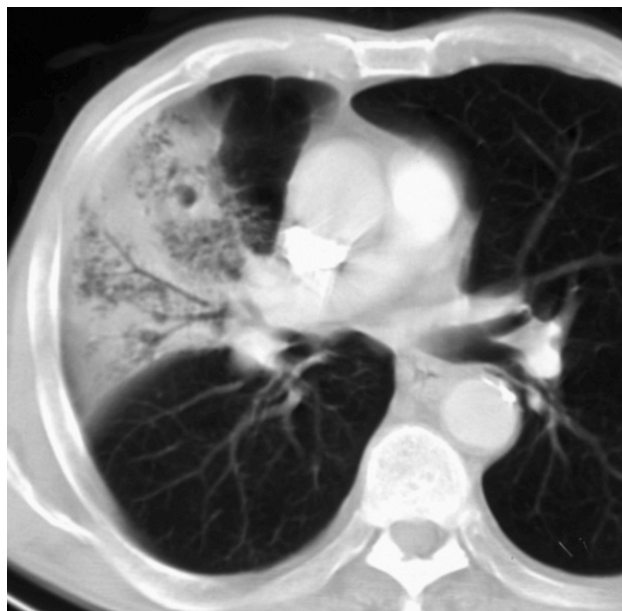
The air bronchogram sign. CT showing an air bronchogram in an area of pulmonary consolidation from pneumonia.
